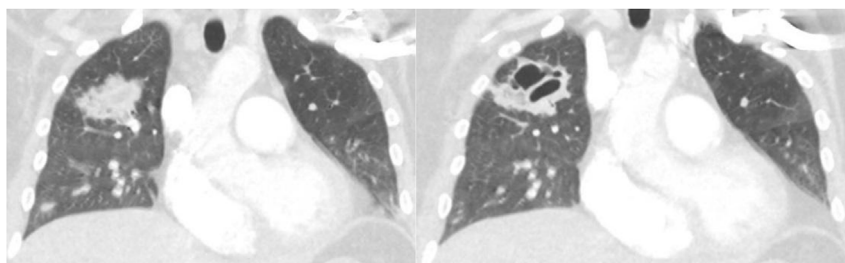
Initial coronal Computed Tomography of the chest showing a right upper lobe wedge-shaped peripheral ground glass and cavitary opacities consistent with pulmonary infarcts.
